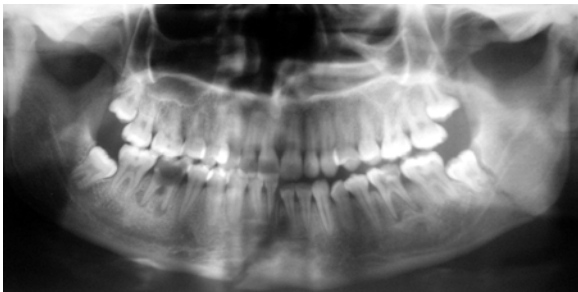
Panoramic radiograph of angle fracture associated with third molar.
